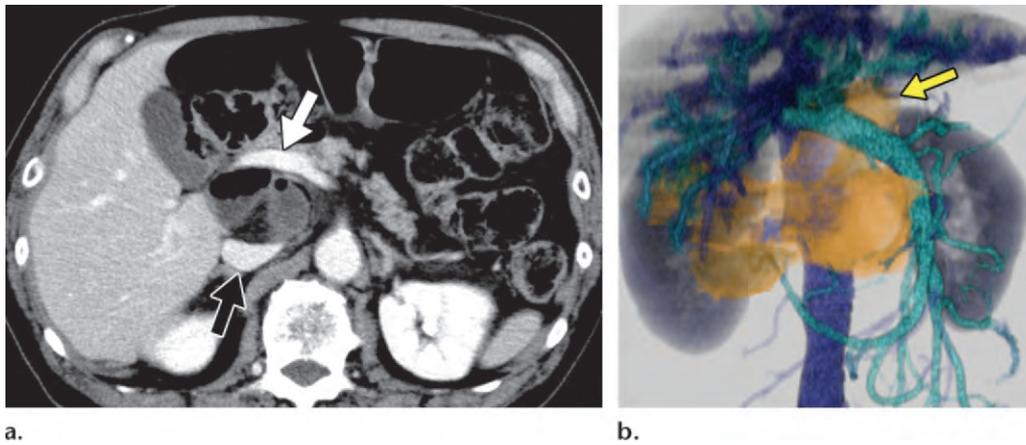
Foramen of Winslow hernia in a 74-year-old man with intermittent abdominal pain. (a) Axial contrast-enhanced CT image shows mesenteric vessels and a cluster of intestine between the inferior vena cava (black arrow) and portal vein (white arrow). (b) Volume-rendered CT image of the intestine (orange), venous system (dark blue), and portal venous system (light blue) shows a short segment of intestine in the superior recess of the lesser sac (arrow) through the foramen of Winslow. The herniation was spontaneously reduced after placement of a long nasointestinal tube. (Case courtesy of Shigeru Furui, MD, and Asako Yamamoto, MD, Teikyo University School of Medicine, Tokyo, Japan.)
